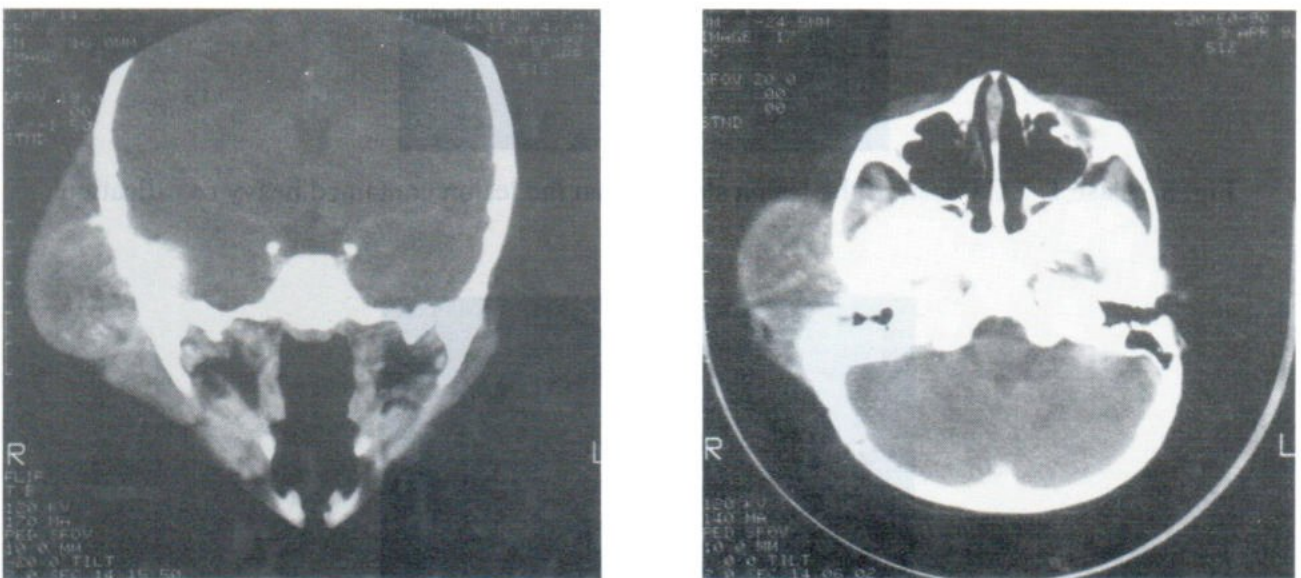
Case 2. The extracranial part of the mass showed minimal calcification by CT scan.
